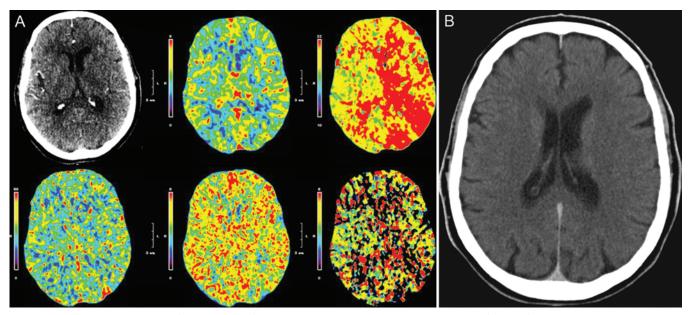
A: Noncontrast CT scan and perfusion maps obtained in a patient with acute stroke from a left internal carotid artery occlusion (NIHSS score 12). The perfusion maps demonstrate markedly increased time-to-peak (upper right) in the left hemisphere but preserved CBV (upper middle), indicating a significant amount of brain tissue at risk (penumbra). The patient subsequently underwent mechanical thrombectomy.
